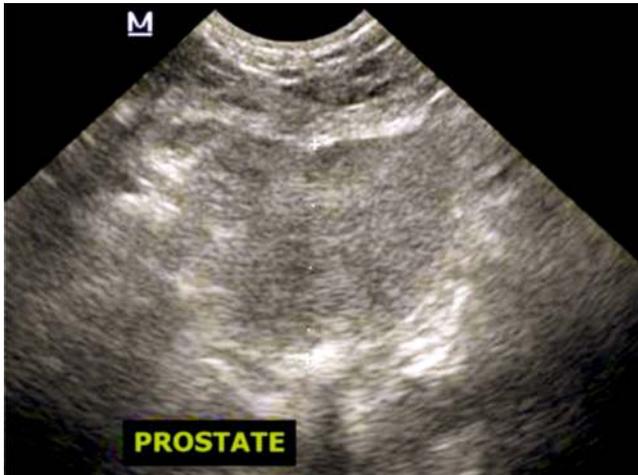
Transabdominal ultrasound image of the prostate of the presented case indicating benign prostatic hypertrophy. The prostate is symmetrically enlarged and normoechoic to slightly hyperechoic
